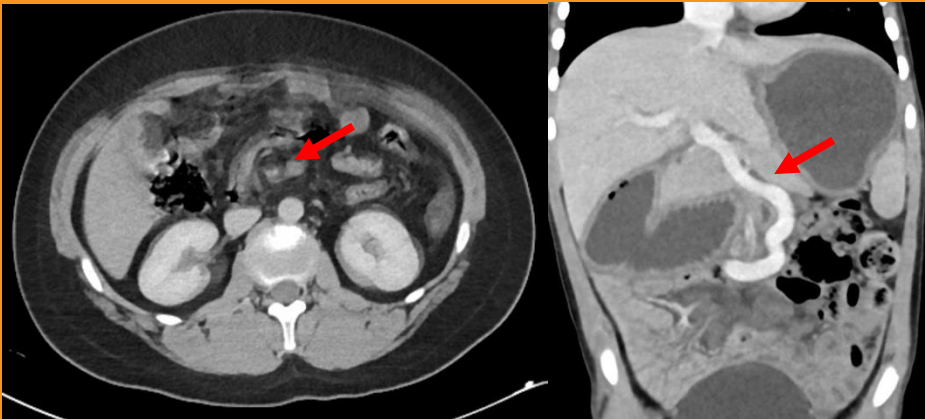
Computed tomography image of two different patient with intestinal volvulus. A whirlpool sign can be seen in the superior mesenteric artery and vein
